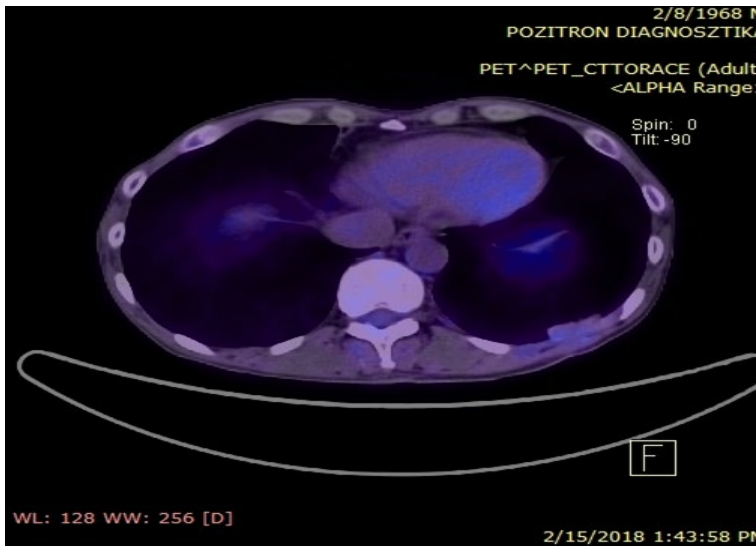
PET-CT (15.02.2018): Complete Response
